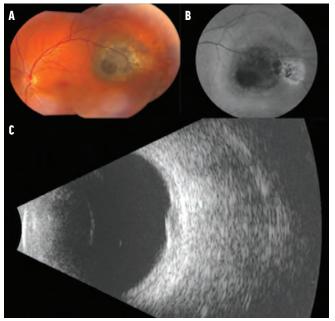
Wide-angle color fundus photography shows a choroidal nevus measuring 8 mm in basal diameter with overlying drusen and RPE hyperplasia in the left eye (A). FAF shows focal patches of hypoautofluorescence overlying the nevus corresponding to areas of RPE hyperplasia and atrophy (B). Ultrasonography shows an echolucent, dome-shaped mass 2.9 mm in thickness (C).
